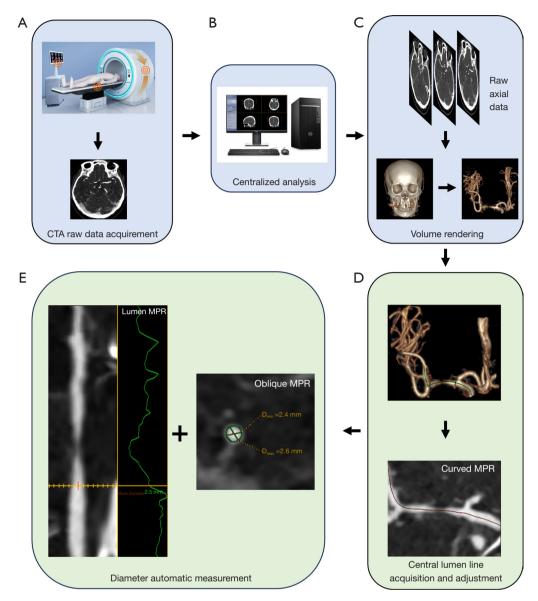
Process framework of imaging data generation and analysis. (A) CTA axial raw data were acquired from 6 centers; (B) imaging data from 6 centers were centrally analyzed by a semi-automated vessel analysis software (Advantage Workstation). The steps of centralized analysis were as followed: a volume rendering image was created from the raw axial data (C); a central lumen line was automatically acquired and manually adjusted (D); diameters (including minimal diameter, maximal diameter, and mean diameter) of stenosis site and reference site were automatically measured (E). CTA, computed tomography angiography; MPR, multiplanar reconstruction.
